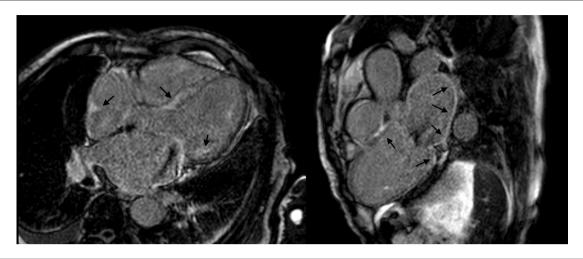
Cardiac magnetic resonance imaging with delayed enhancement of non-ischemic appearance, predominantly in the basal portions of the left ventricle, right ventricle, and atria (arrows).
